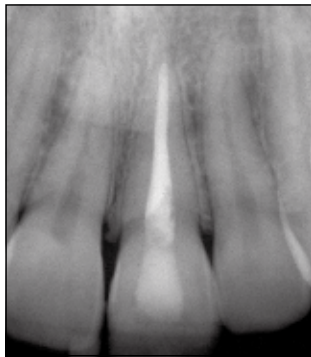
Postoperative radiograph of teeth No. 8 and 9.
